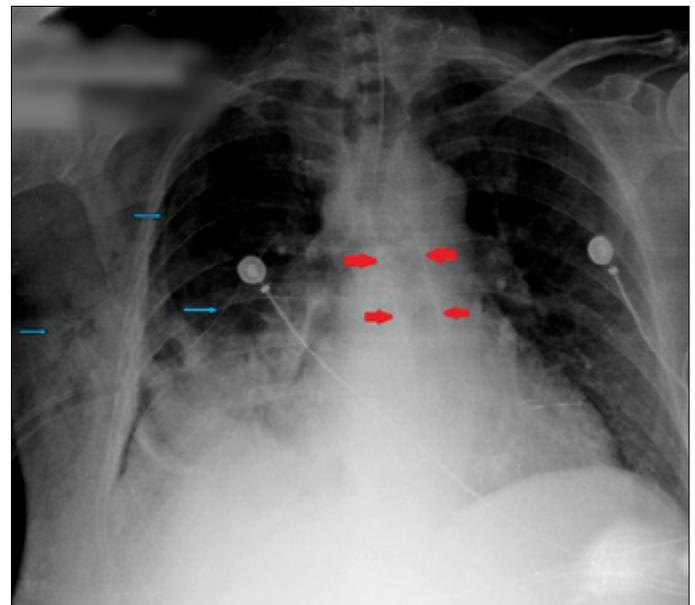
Chest X-ray showing the right chest pneumothorax, subcutaneous air and chest tube (*small arrows*); metal stent in the esophagus (*big arrows*)
